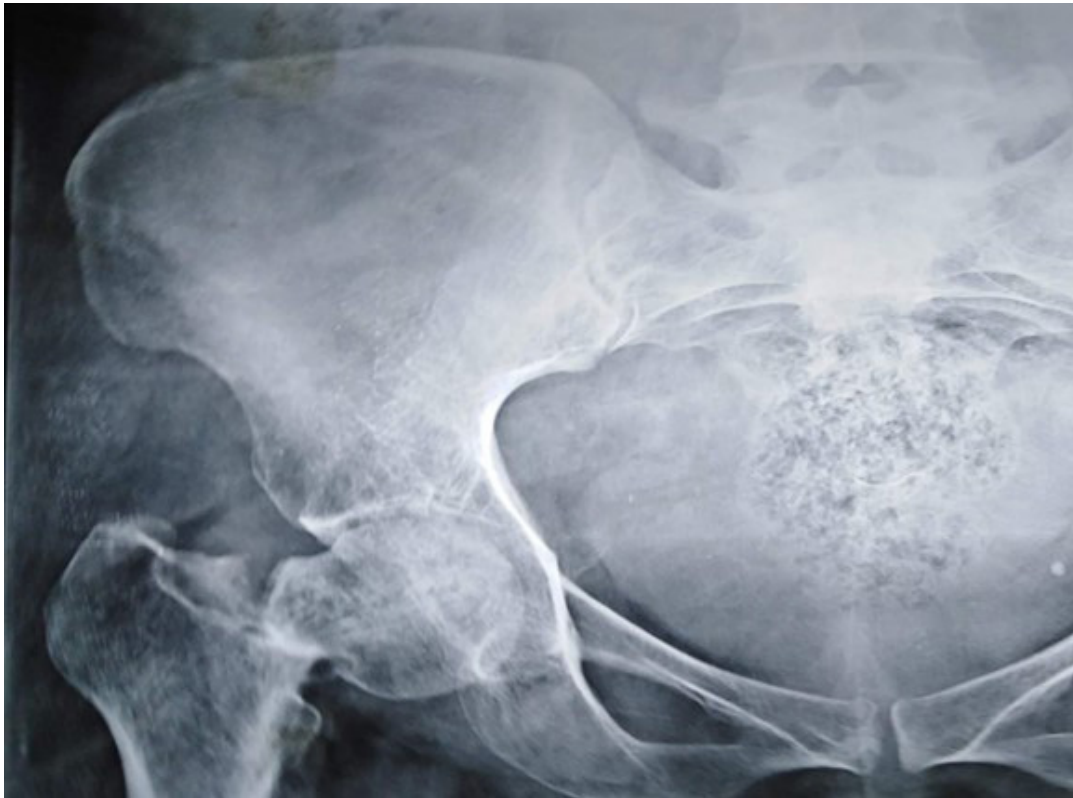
Pre-operative right radiograph of 32 years old male patient, presented after 6 weeks of neglected neck of the femur fracture.
